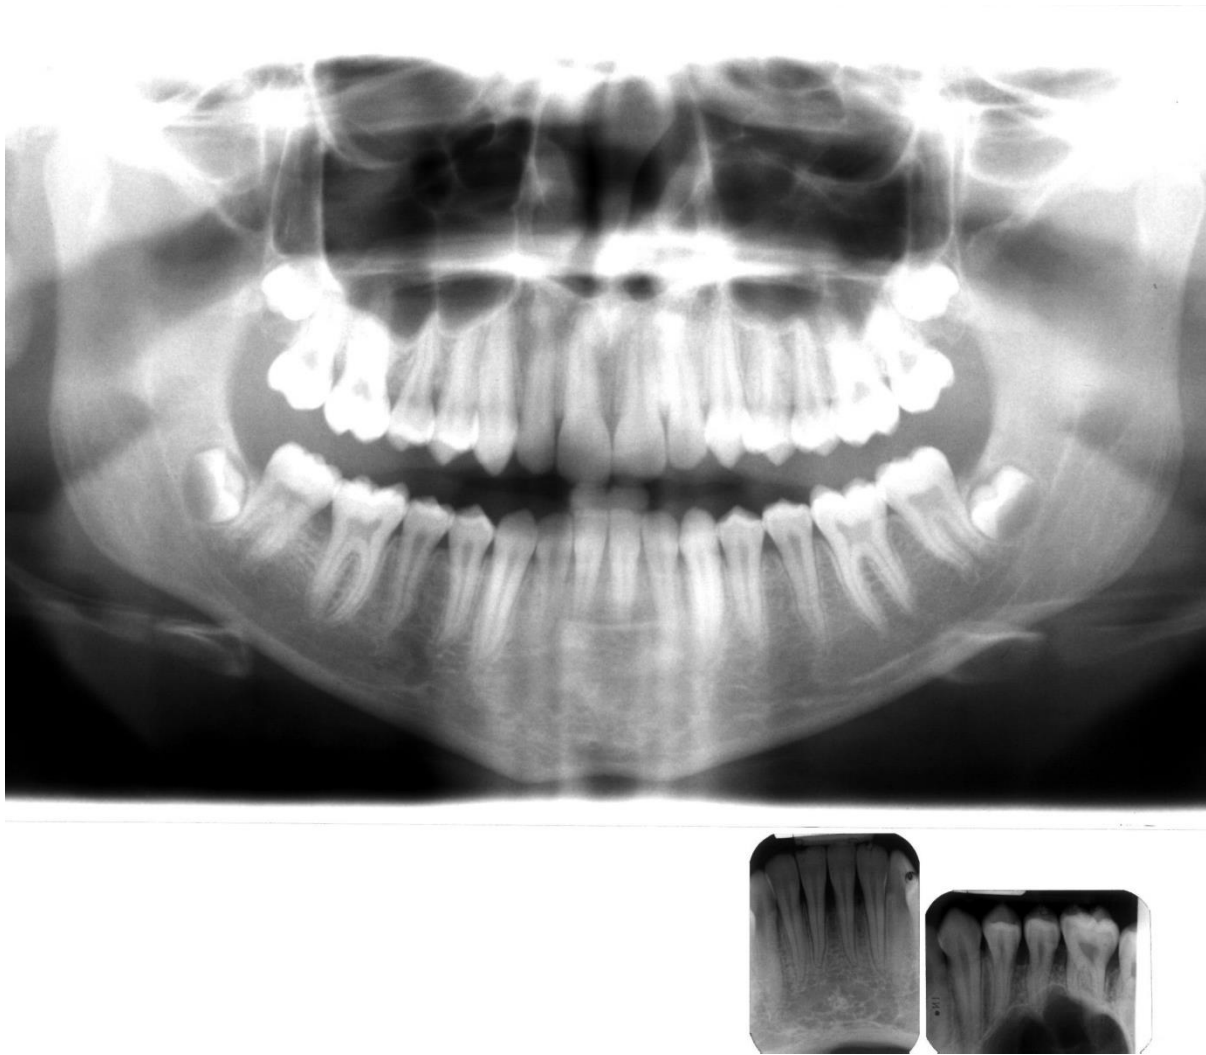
Case 2 - Panoramic radiograph and selective periapical radiographs
